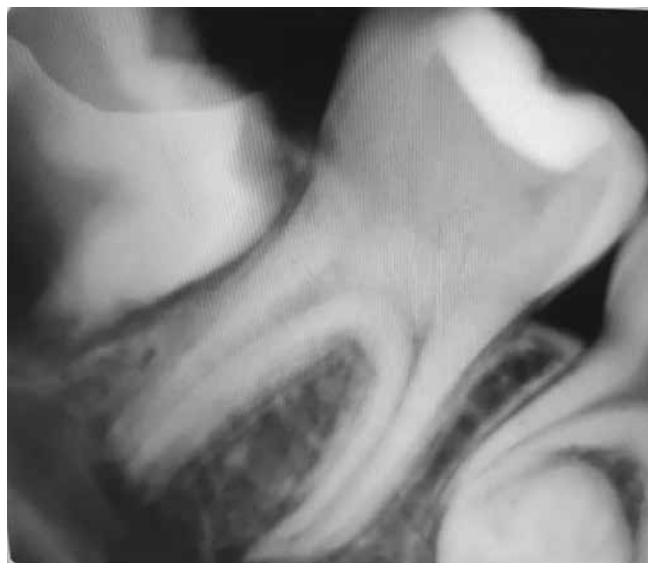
Follow-up radiographs after 3 and 6 months
